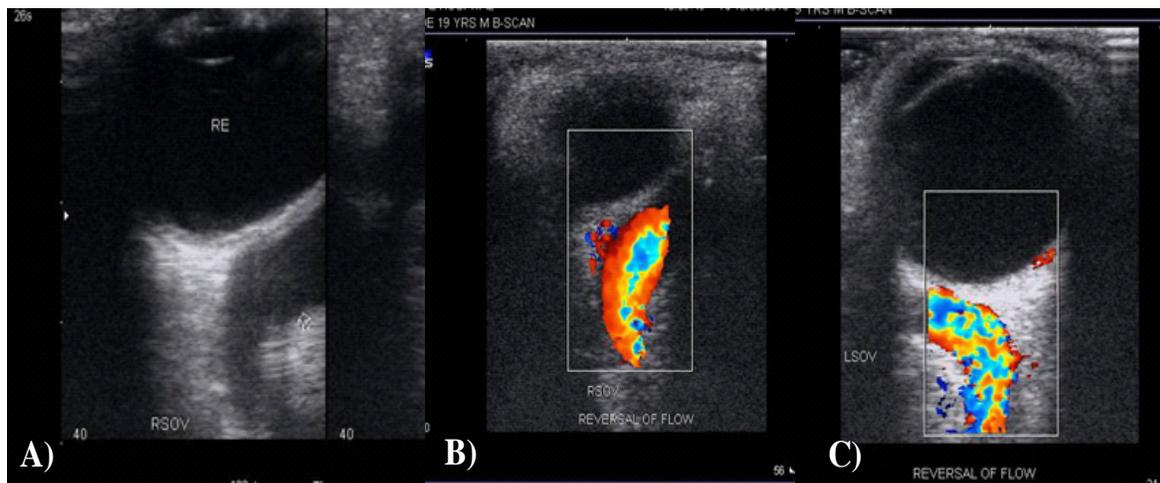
Color Doppler study of eye ball showing congested and dilated ophthalmic veins
